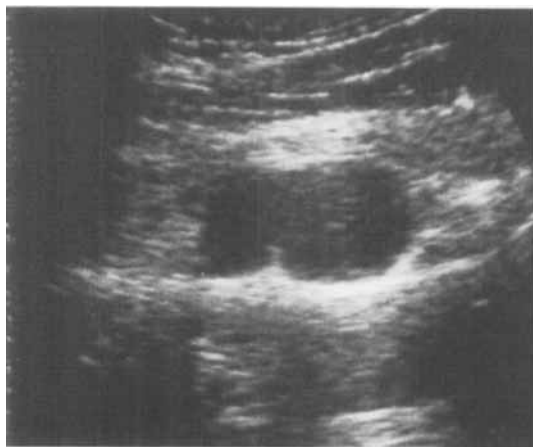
Cystic lesions are demonstrated on an ultrasonogram.
